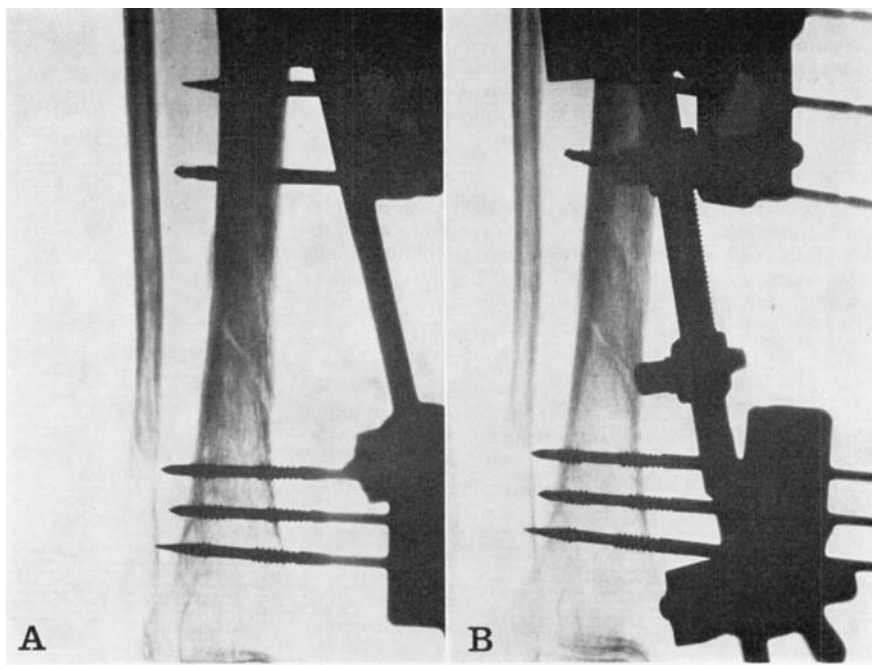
X-ray examination of the crural fracture in case no. 1. A: 5¼ months after the fracture development of a severe reflex sympathetic dystrophy. B: The clinical signs of dystrophy and the X-ray visible osteoporosis disappeared after 3 weeks of axial compression of the tibia.
